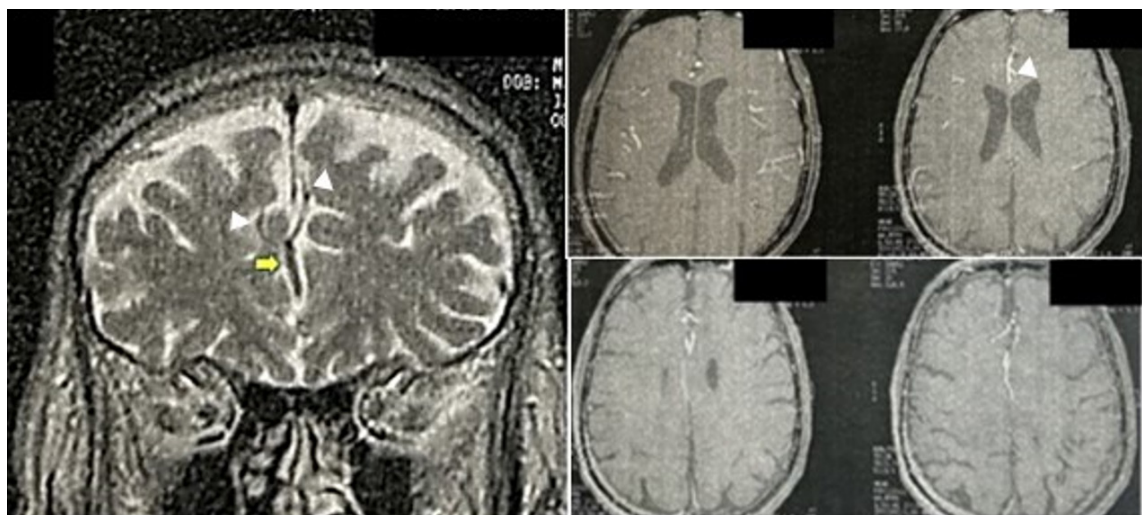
The MRI of the brain reveals an azygos anterior cerebral artery. Left panel, coronal T2W. Observe that the azygos anterior cerebral artery (yellow arrow) bifurcates into distal pericallosal branches, as the arrowheads indicate. Right panel, axial T1W with intravenous Gd-contrast MRI of the brain reveals an azygos anterior cerebral artery, as indicated by the arrowhead.
